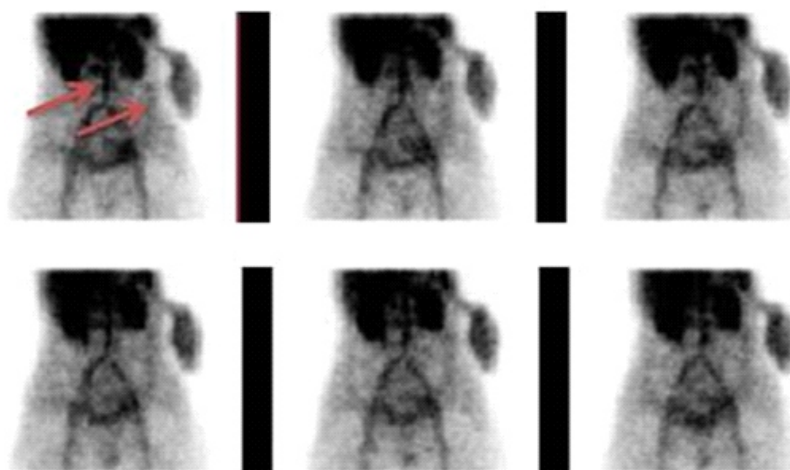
Dynamic scintigram of the abdomen. Arrows indicate the signs of intestinal hemorrhage in the small and large intestine.
